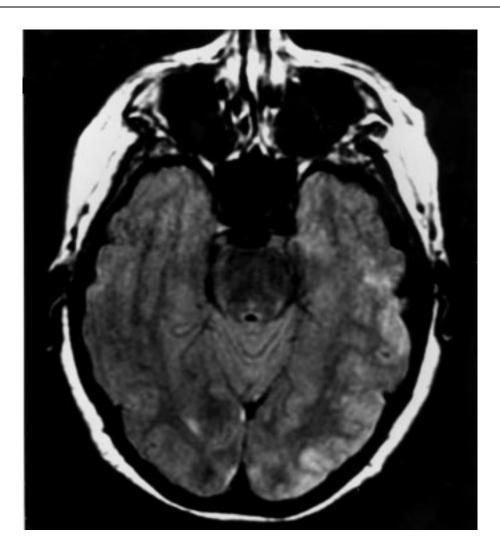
T2 weighted MRI axial images demonstrating hypodense lesions consistent with infarctions of the temporal lobe.
